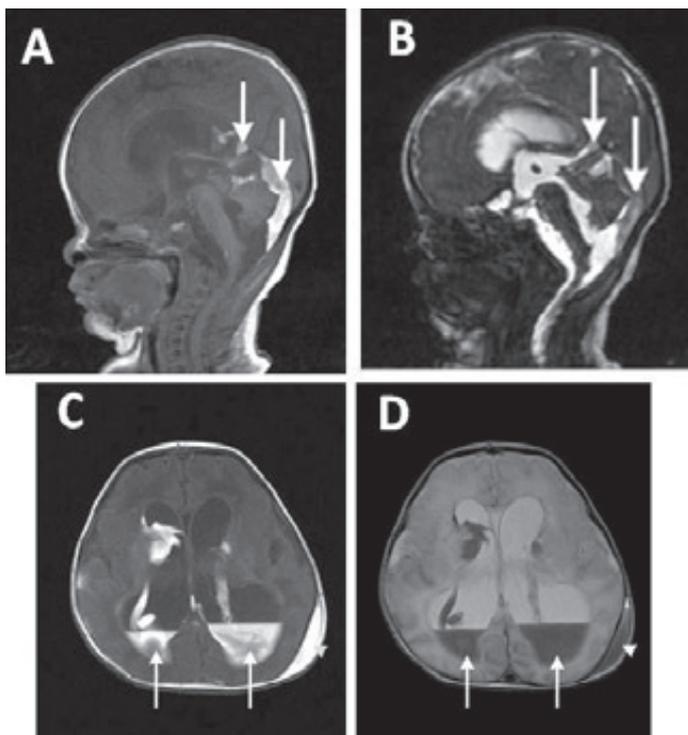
MR images of the head of a very low birth weight infant nine days after birth. A: Sagittal T1-weighted MRI showing layering of the intraventricular haemorrhage within the ventricles and in the posterior fossa (arrows). B: CISS (Constructive Interference in the Steady State) sequence giving heavily T2-weighted high resolution images with excellent fluid contrast demonstrating the dilated ventricular system in white and the dependent haemorrhage (arrows). C: T1-weighted axial MRI scan showing layering of the intraventricular haemorrhage (arrows) and a left scalp haematoma (arrowhead). D: T2-weighted axial MRI showing layering of the intraventricular haemorrhage (arrows) and a left scalp haematoma (arrowhead). The most striking features on these scans are hydrocephalus with intracranial haemorrhage, which is seen layering within the lateral ventricles.
